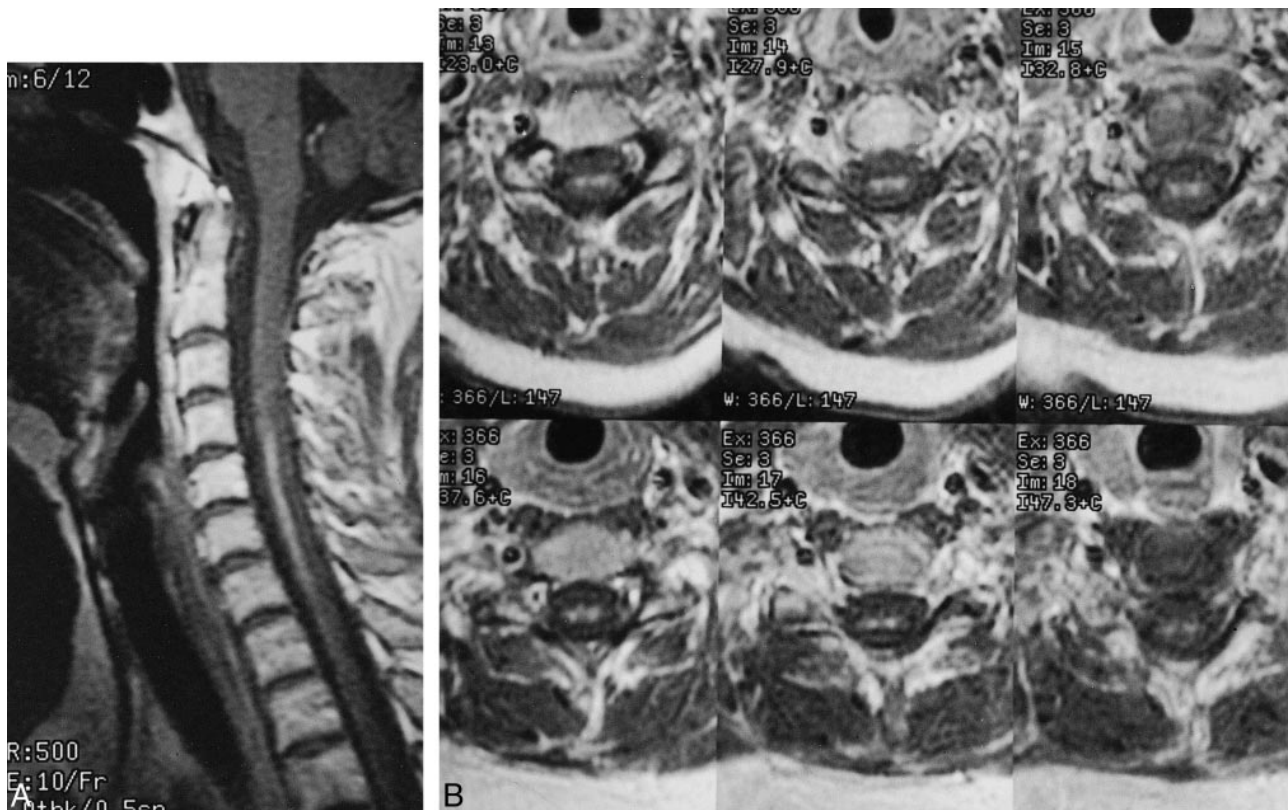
Case 3: Cervical spine MR imaging performed 2 months after onset of neck pain, left upper distal extremity dysesthesia and paresis in patient 3. Symptom onset occurred 4 days after a vertebral disruption and chemotherapy. The patient's initial MR study showed findings similar to those in Figure 1 (case 2).
